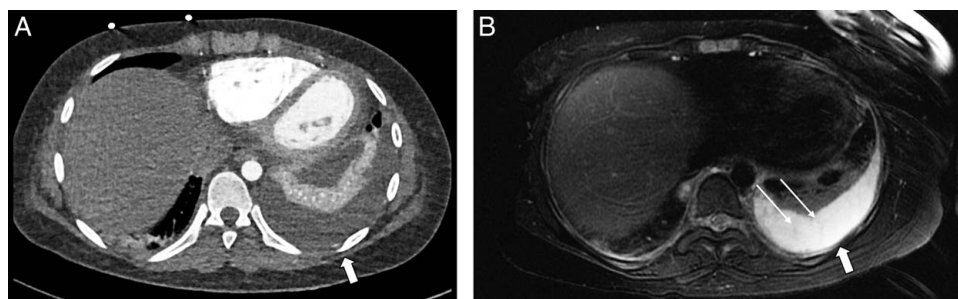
A 17-year-old girl with empyema due to retropharyngeal abscess complicated by pneumonia with septic emboli. A, Axial enhanced soft tissue window setting CT image shows left pleural effusion (arrow). B, Axial nonenhanced T2-weighted fat suppressed MRI shows left pleural effusion (wide arrow) containing thin septations (thin arrows) not visible on CT.
